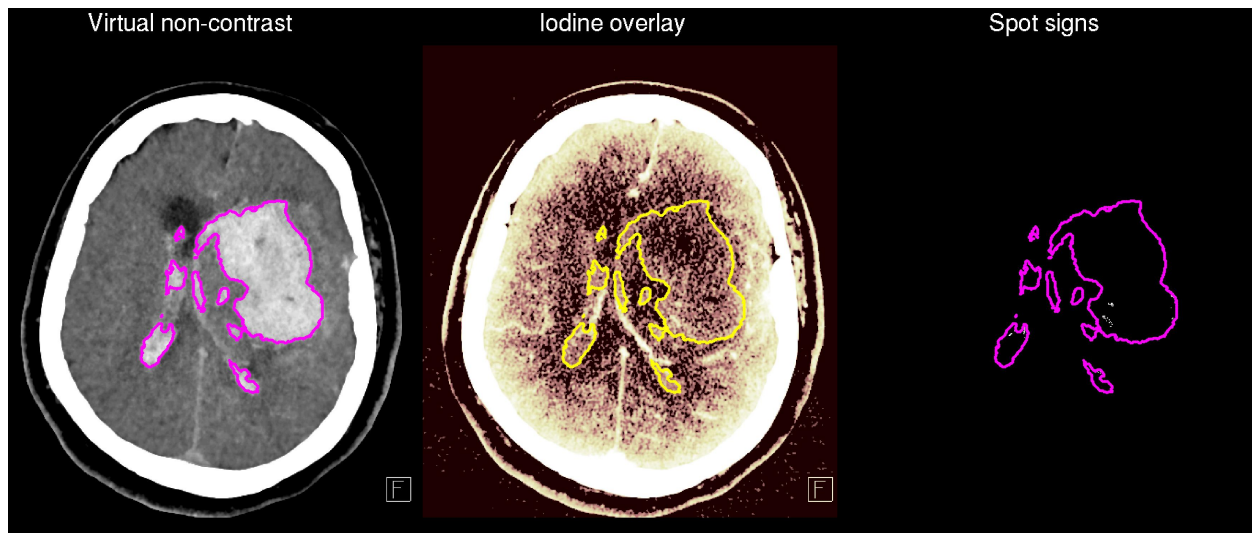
A case (#8 on Table 1) showing the automated classification and characterization of spot-signs. In this case, automatically identified hematoma volume was 97 cm³, and the total volume of spot signs was 148 mm³ (i.e., <0.15% of the total hematoma). Follow-up head CT showed expansion of hematoma. Spot signs were identified statistically, based on the intensities of pixels on the iodine overlay image compared to those of overall hematoma ROI.
